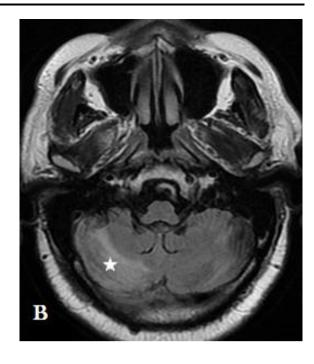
Cerebral MRI in T2 FLAIR sequences (A and B) and post-contrast T1 (C). A: The image shows hypothalamic hyperintense lesions, which extend to optic nerves (arrow).
